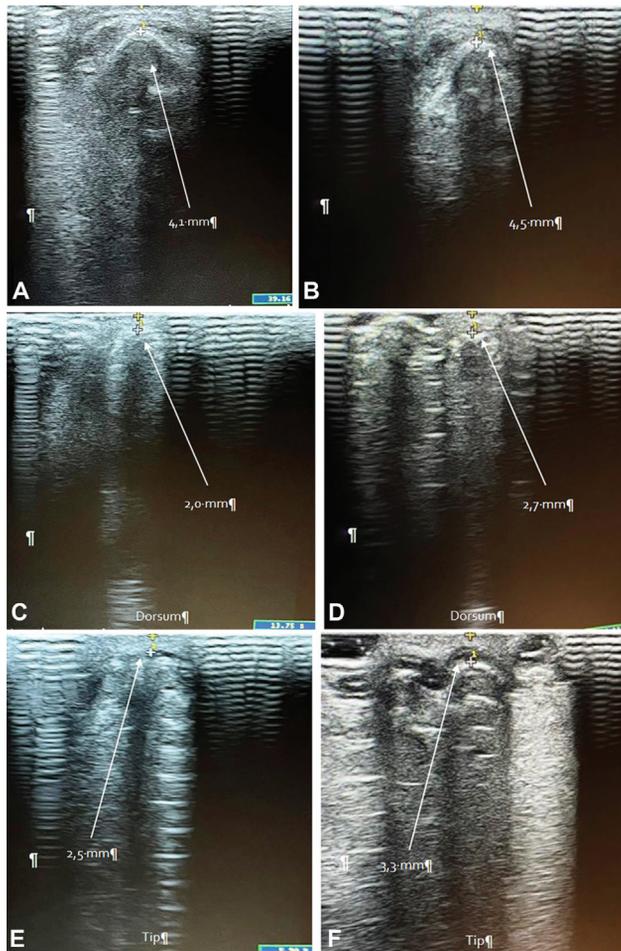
Ultrasound images of the nose of a 30-year-old woman immediately before treatment and 8 months after treatment. Nasion (A, B), nasal dorsum (C, D), nasal tip (E, F).
